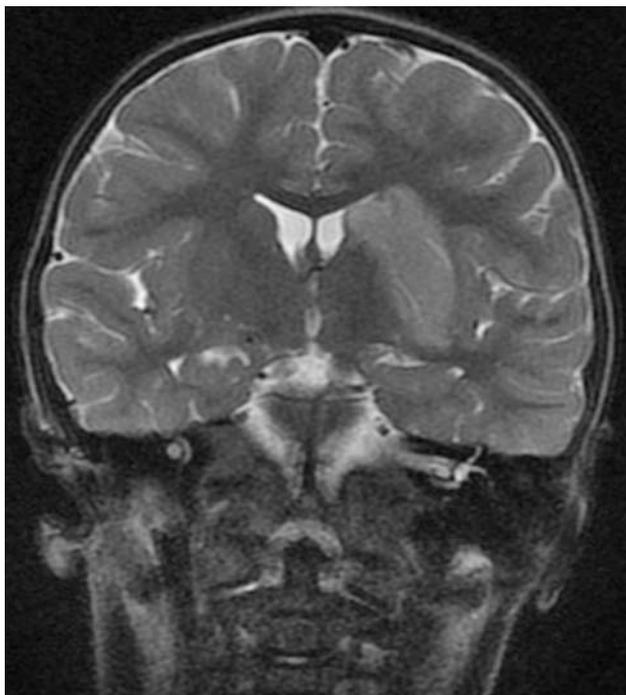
Coronal T2-weighted MR image shows a focus of high signal intensity in the left-sided basal ganglia and internal capsule area compatible with infarcted tissue in the territory supplied by the lenticulostriate arteries
